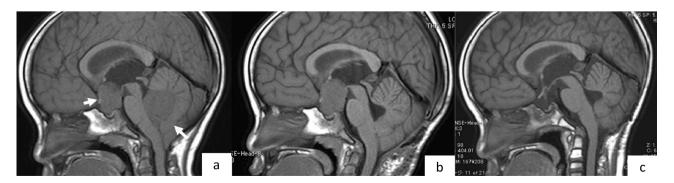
Sagittal magnetic resonance T1-weighted images obtained at the initial presentation. Arrows indicate homogeneous hypointensity in tumours in the suprasellar region and vermis (a). Image after removal of the tumour in the vermis (b) and following chemotherapy and radiation therapy, showing resolution of the tumour in the suprasellar region (c).
